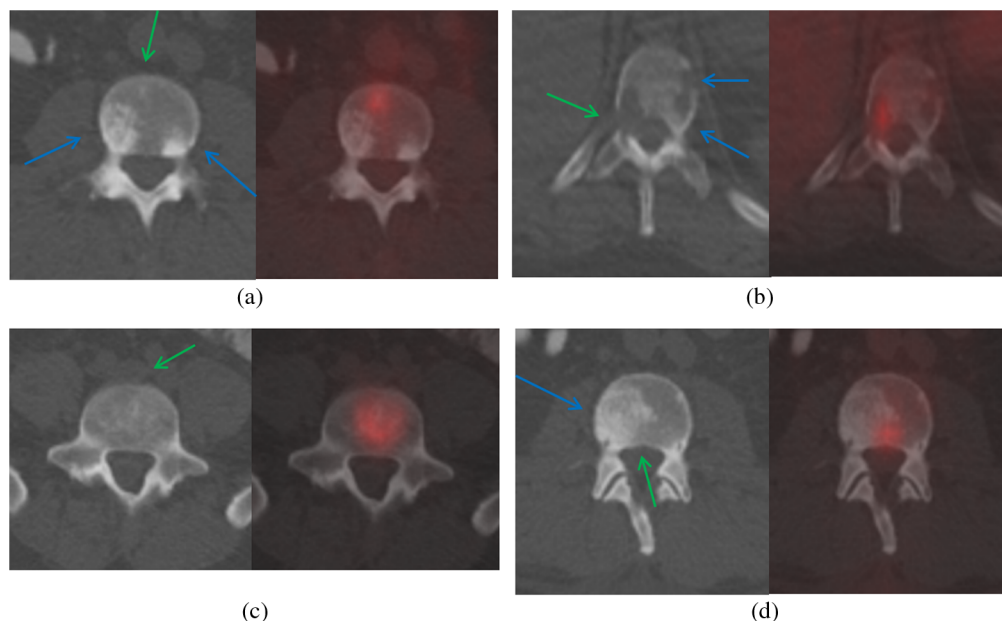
Spine metastases on PET/CT. (a) and (c) CT and (b) and (d) PET/CT fusion. (a) Multiple sclerotic lesions, two without PET activity (blue arrows), one showing PET activity (green arrow); (b) multiple lytic lesions, one showing PET activity (green arrow), two not showing activity (blue arrows); (c) mixed lesion showing heterogeneity; and (d) mixed lesion with both sclerotic (blue arrow) and nearly imperceptible lytic components (green arrow).
